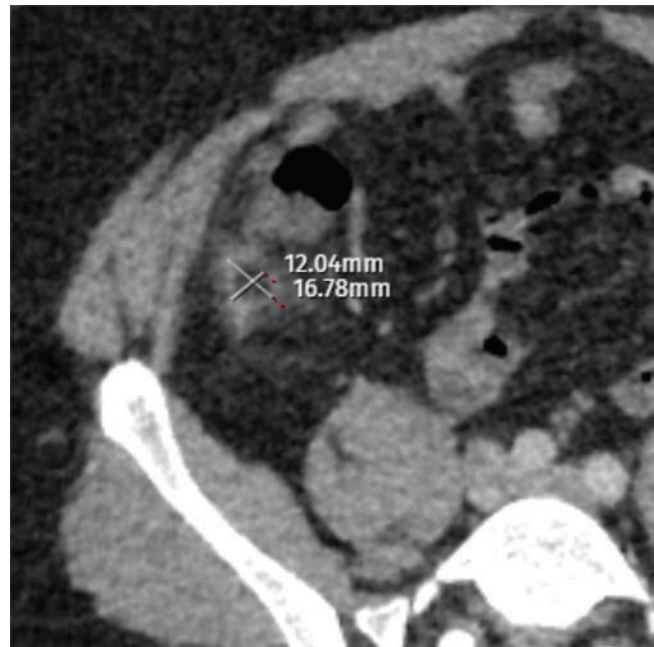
CT imaging. Fat necrosis? Mesenteric infarction? Area at the distal vermiform appendix.
